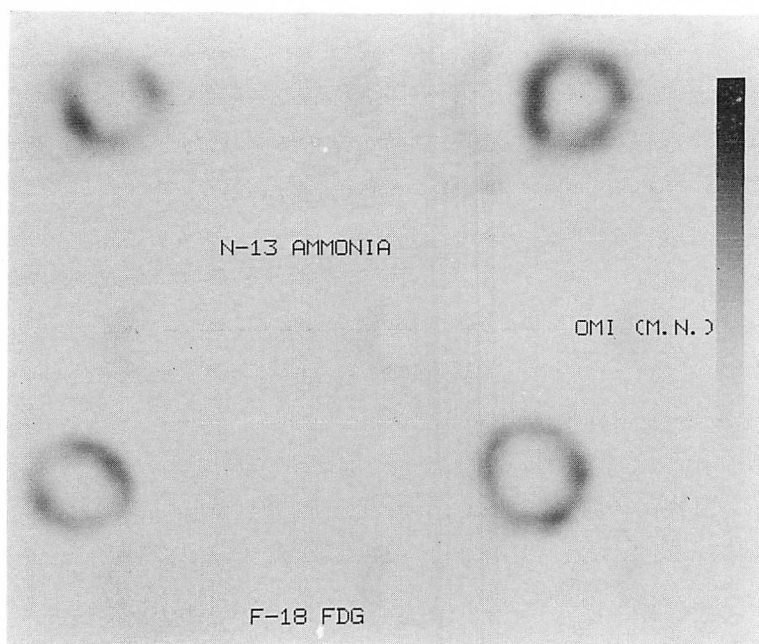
Two representative short-axis slices of N-13 ammonia perfusion and FDG-PET images of the same patient as Fig. 4.
